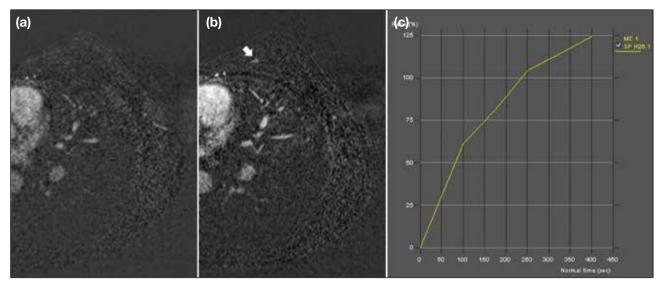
A 28-year-old female with known Li-Fraumeni syndrome and a family history of breast cancer. She had a history of left ovarian teratoma and right primary ovarian neuroectodermal tumour treated with salpingo-oophorectomy at 12 years and 13 years of age, respectively. A germline *TP53* gene mutation was detected; therefore, she underwent magnetic resonance imaging (MRI) screening for breast cancer (a). A T1-weighted post-contrast MRI with subtraction shows linear non-mass enhancement in the left breast 11 o'clock position (arrow) which demonstrated a type I enhancement curve, new since her prior MRI 2 years ago (b). There was no mammographic or sonographic correlation. MRI-guided vacuum-assisted biopsy showed atypical glands. Surgical excision was performed and confirmed high-grade ductal carcinoma in situ, indicating that a type I-enhancing kinetic curve does not exclude a malignancy (c).
